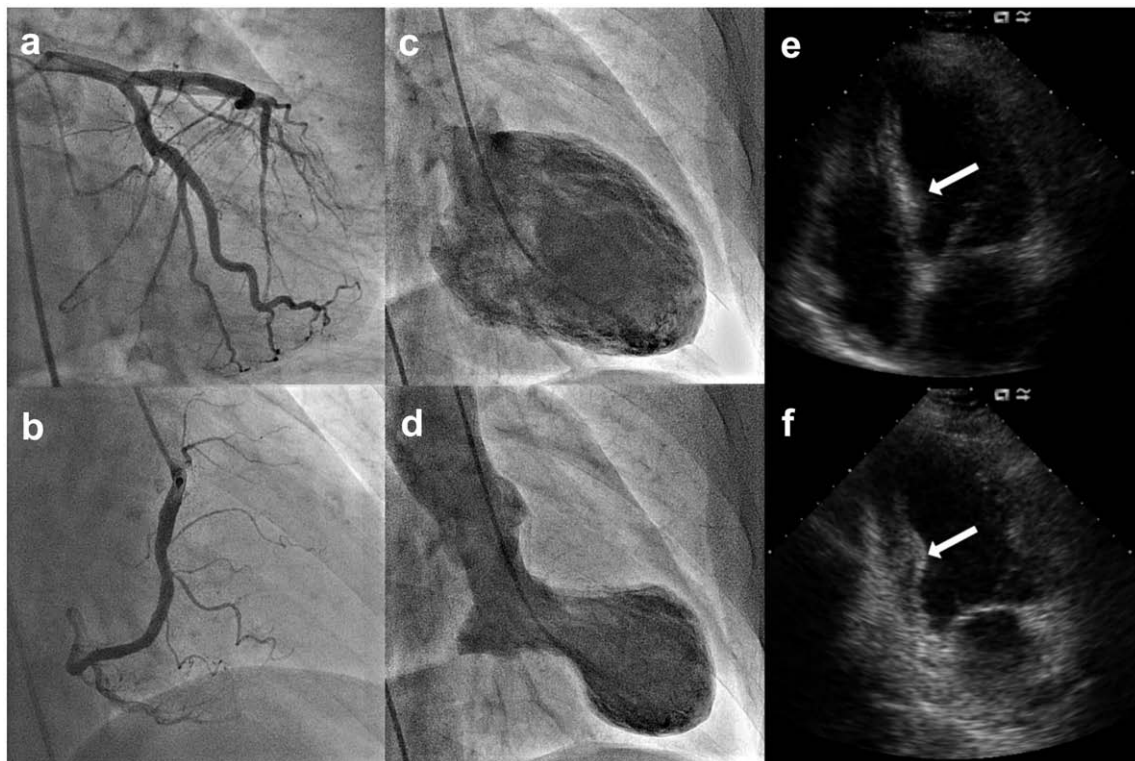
Coronary angiography revealed no significant stenosis in the left (a) and right (b) coronary arteries. Left ventriculography disclosed apical ballooning with basal hyperkinesis (c,d). Transthoracic echocardiography showed a sigmoid deformity of the interventricular septum (e,f).
